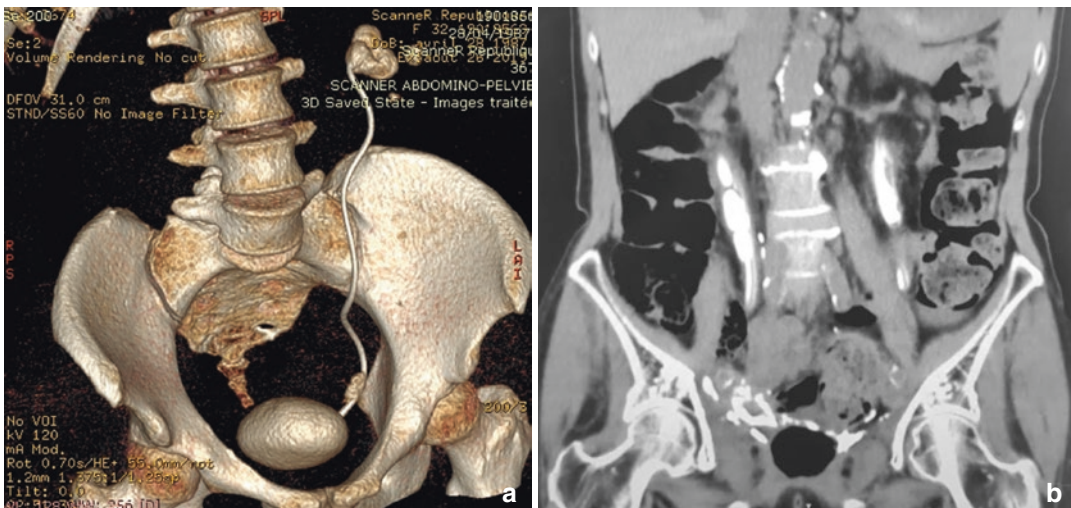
(a) 3D reconstruction image of an incrustated stent in the left kidney, lower ureter, and bladder. (b) CT image in coronal view demonstrating bilateral encrusted stents
